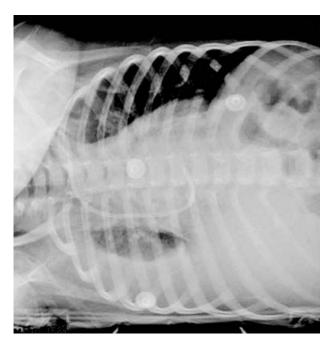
Pleural effusion A six years old boy with Dengue shock syndrome. The right lateral decubitus chest x-ray shows pleural effusion with 34% pleural effusion index.
